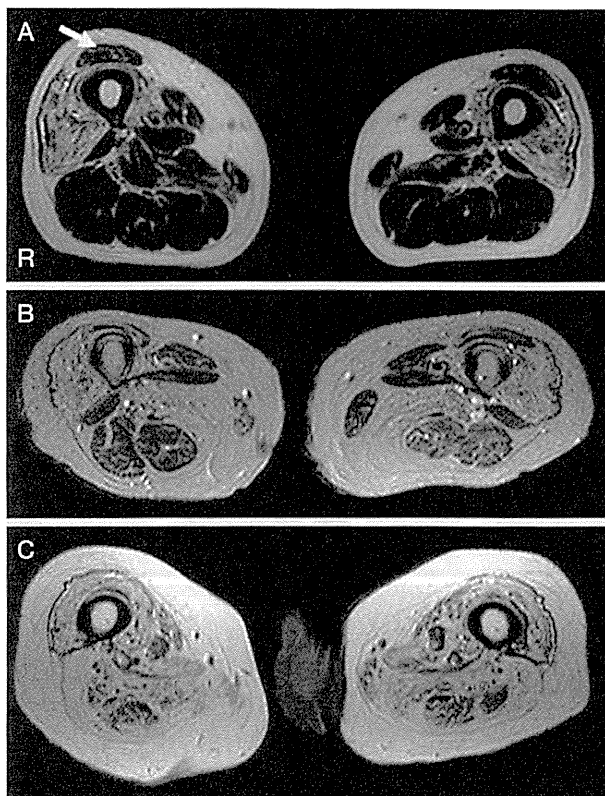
封入体筋炎症例の大腿部 T₁ 強調 MRI 画像
